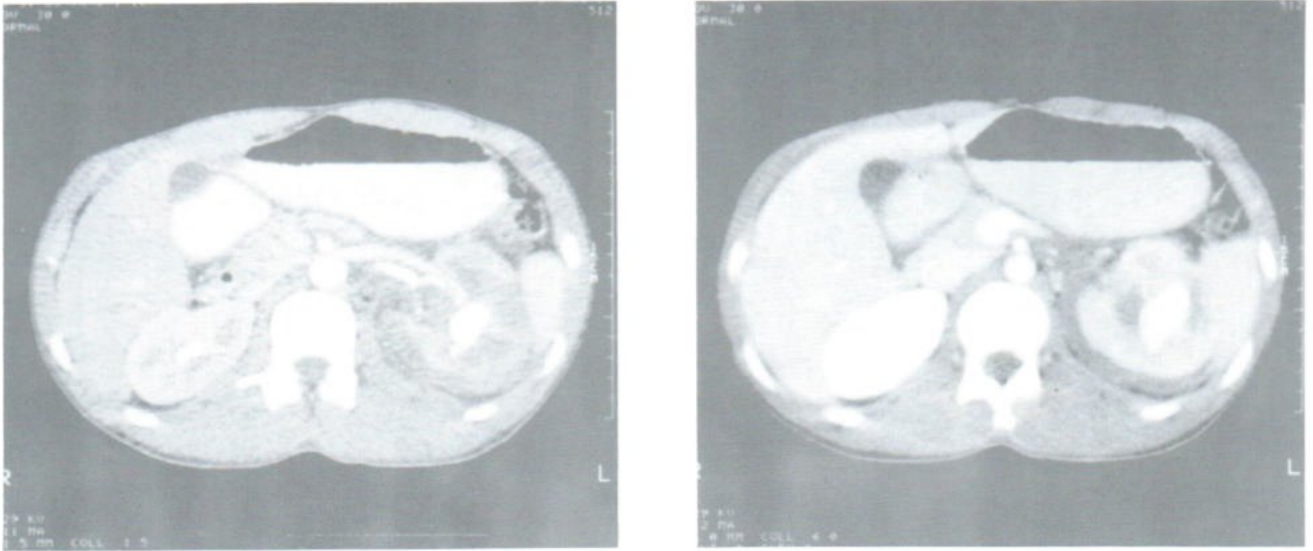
Early and late arterial phase ultrafast CT scan of the kidney showed a large pseudoaneurysm with an early draining vein, representing an AV fistula.
